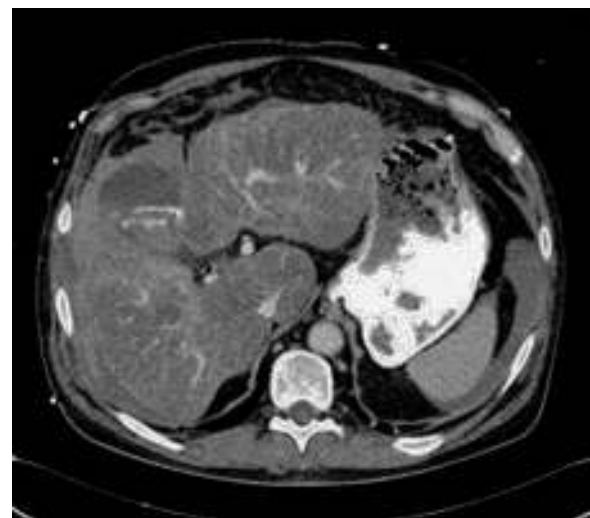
Abdominal CT scan: hyperdense perihepatic fluid; distended gallbladder and active extravasation of contrast material in its interior.
